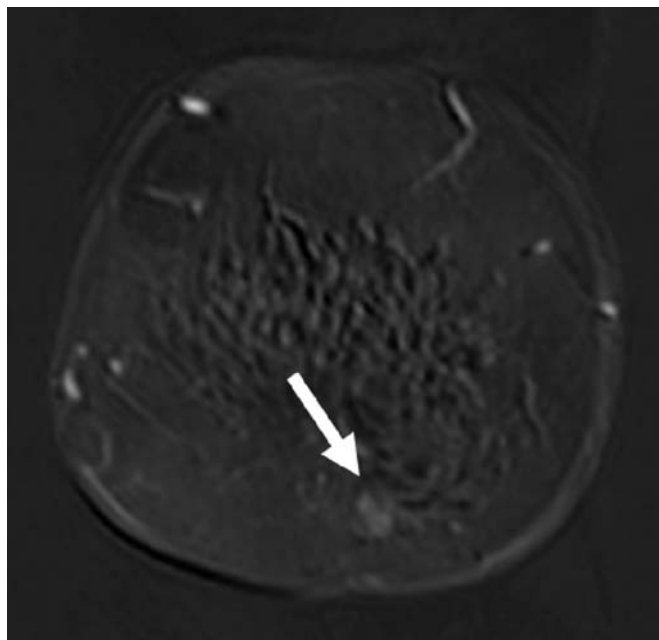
Benign papillomas. a)FLASH T1 enhanced MRI subtracted image demonstrates a small well-defined slightly enhancing mass in the lower quadrants of the left breast (arrow). Sonographically-guided core-needle-biopsy diagnosis was benign papilloma and it was confirmed at surgical excision.
